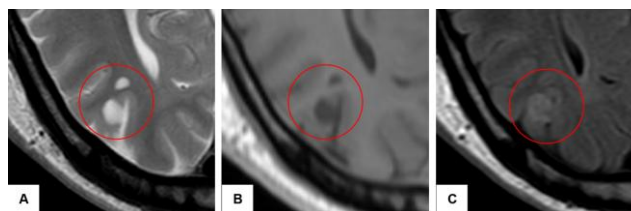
(A) T2-weighted (B) T1-weighted and (C) Fluid-attenuated inversion recovery (FLAIR) MRI. There are multiple well-defined cortical-based lesions. These appear hyperintense on T2-weighted and FLAIR imaging and are hypointense on T1-weighted sequences. No associated vasogenic oedema or mass effect is seen
